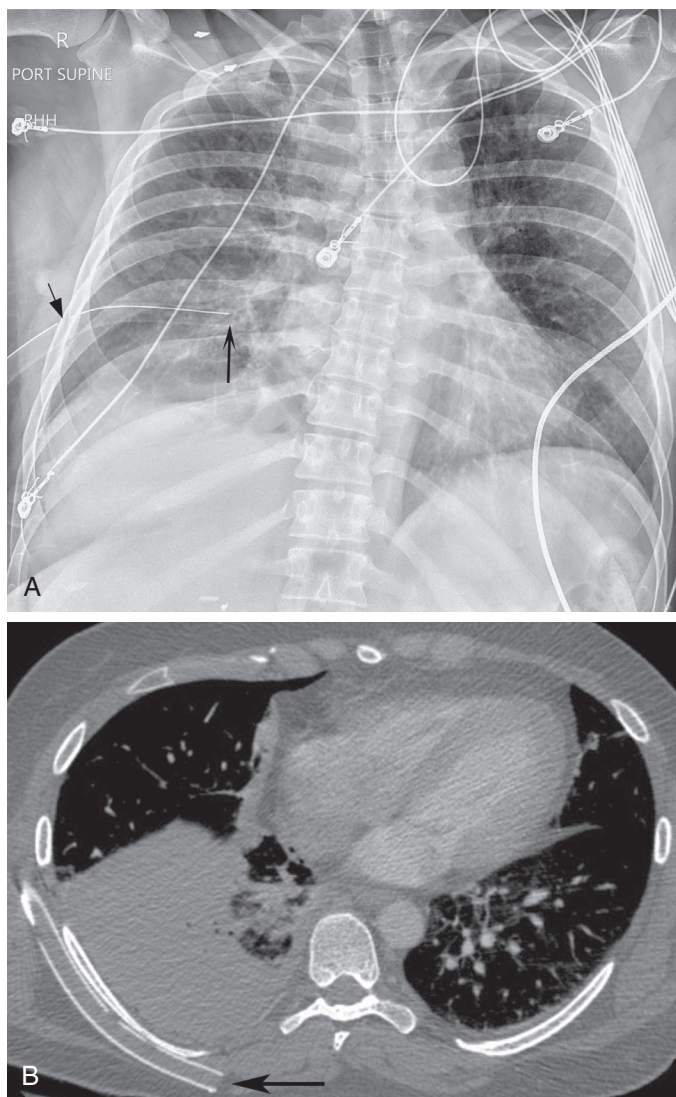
■ A, Anteroposterior (AP) supine chest x-ray. Chest tube tip (*large arrow*) appears to be within the right chest cavity. Note that the side port (*small arrow*) overlies the right lateral ribs and does not appear within the hemithorax. Right pleural effusion obscures right hemidiaphragm. B, Axial computed tomography (CT) slice. Same patient showing chest tube tip (*small arrow*) is actually outside of chest cavity within the soft tissues of the back.
